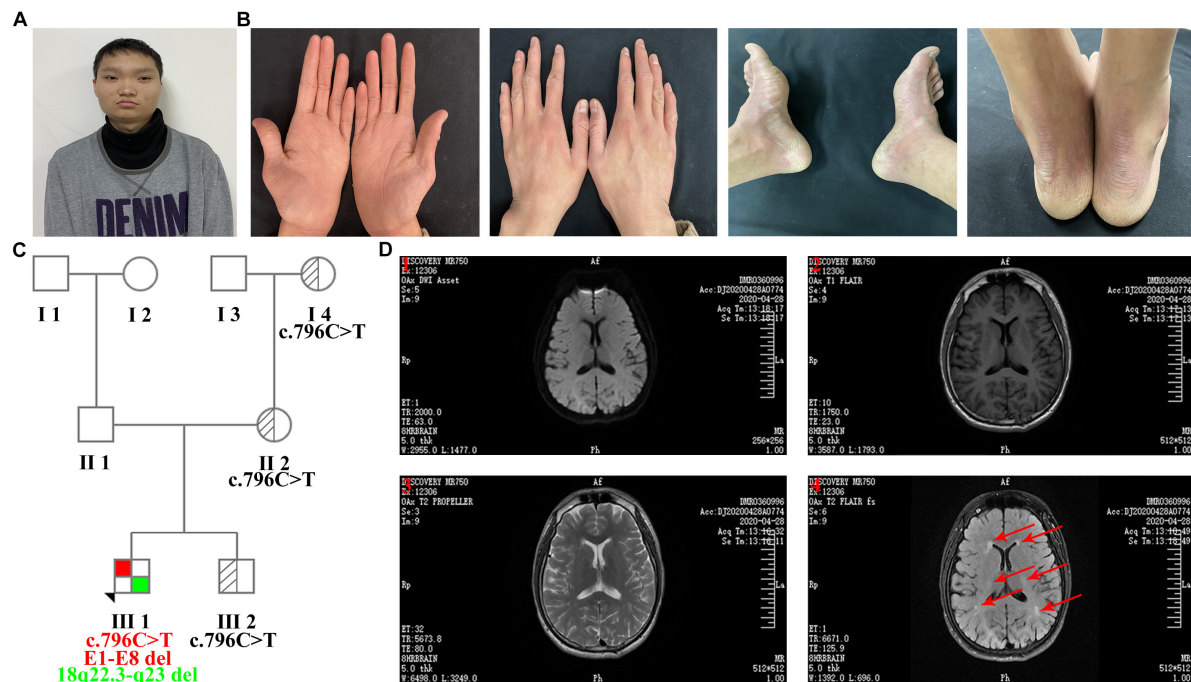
Clinical features of the proband. (A) Facial features: wide-set eyes and short philtrum. (B) Bilateral erythema and hyperkeratosis of the hands and feet. (C) Family tree (E1-E8 del: exon 1-exon 8 deletion). (D) MRI images of transverse views. (1) Diffusion-weighted imaging (DWI); (2) T1 weighted image (T1WI); (3) T2 weighted image (T2WI); (4) Water image. MRI images indicated that the proband had multiple abnormal signals in the bilateral frontal and parietal lobes, and red arrows represent the regions of brain white matter abnormality.
